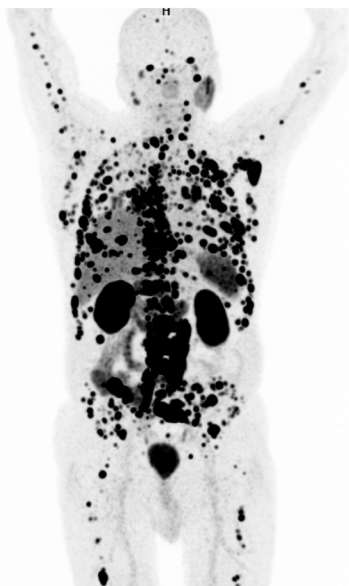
PET/CT ( $^{68}\text{Ga}$ -PSMA-11) before treatment: High PSMA expression in bone lesions and abdominal lymph nodes. PSMA: Prostate-specific membrane antigen.
